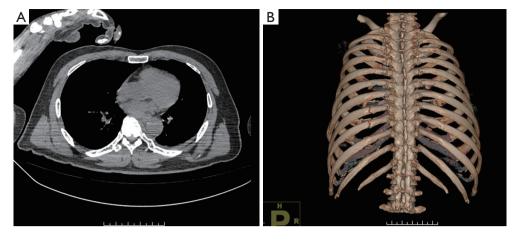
On the day of injury, RFs with dislocation and injuries to the aorta were absent on the chest CT. (A) CT displayed a bicortical fracture of the left 7^{th} posterior rib, the broken end of which did not threaten the aorta, and no obvious free bone fragments; (B) threedimensional rib imaging showed no obvious fracture dislocation of the 7^{th} posterior rib or free bone fragments. RFs, rib fractures; CT, computed tomography.
